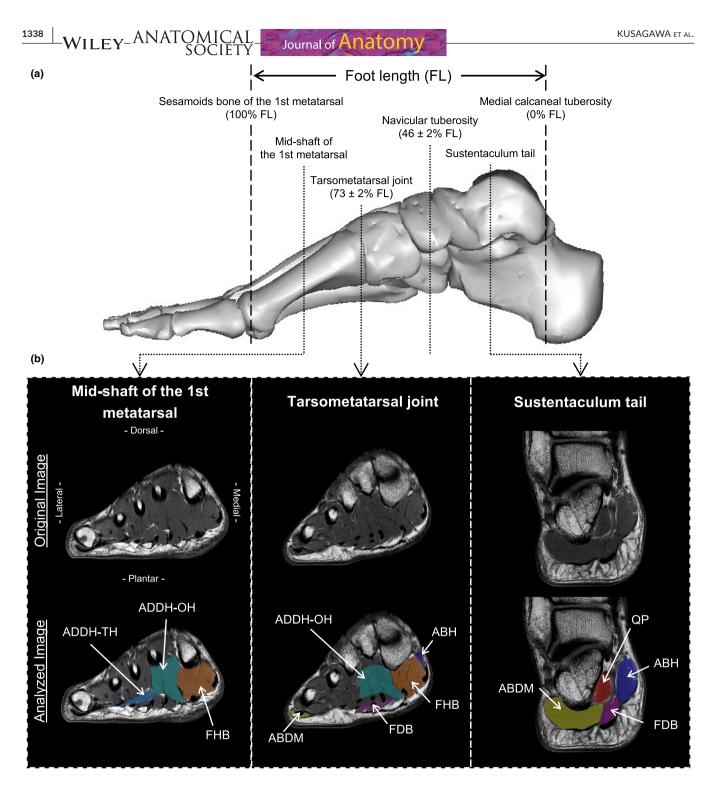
Definitions of foot length (a) and T1-weighted MR images (b) of the right foot. ABDM, abductor digiti minimi; ABH, abductor hallucis; ADDH-OH, adductor hallucis oblique head; ADDH-TH, adductor hallucis transverse head; FDB, flexor digitorum brevis; FHB, flexor hallucis brevis; QP, quadratus plantae. The foot images in the A was created using "BodyParts3D, © The Database Center for Life Science licensed under CC Attribution-Share Alike 2.1 Japan."
